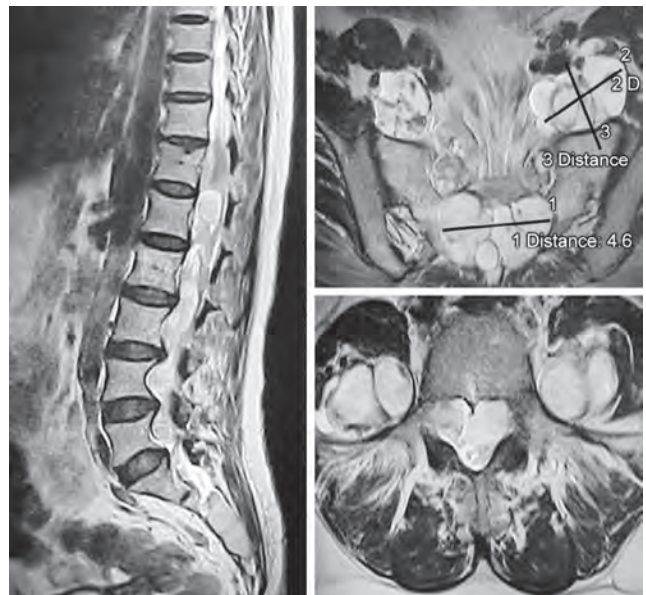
Magnetic resonance imaging of lumbosacral region showing multiple neurofibromatosis
